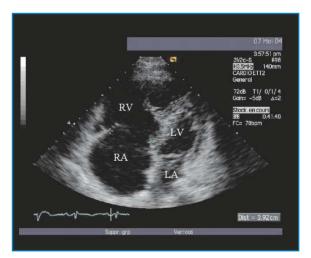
Transthoracic ecochardiographic findings in HIV-associated pulmonary hypertension. A systolic flattening of the interventricular septum and right atrial and right ventricular enlargement can be observed
